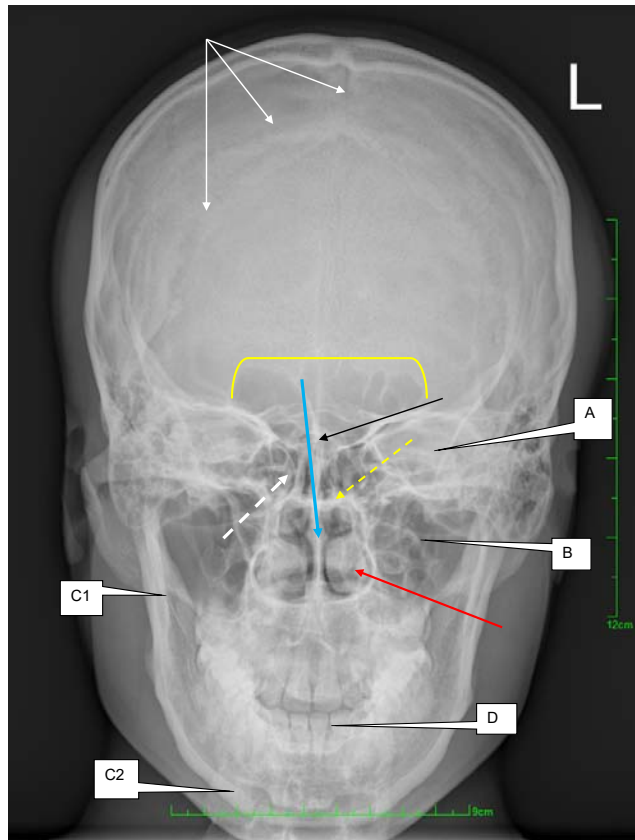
Antero-posterior radiograph of the skull.
